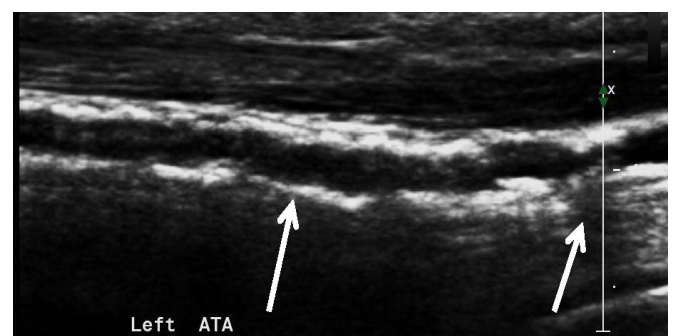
Ultrasound conducted for ankle sprain of Athlete 2. Arrows indicate echogenic intima-media calcification (beads) in the left anterior tibial artery [Note posterior shadowing in sections as the deposits become denser]
